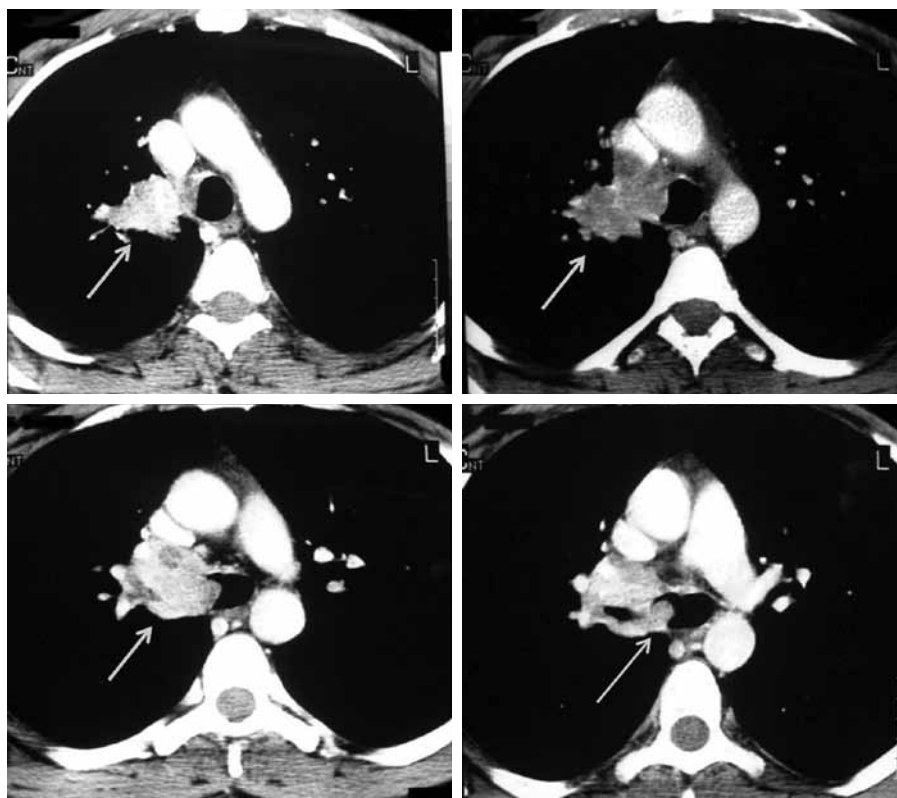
Thoracic computed tomography of patient no 5 in the table 1: A tumor invading proximal right main bronchus and lower end of trachea.
